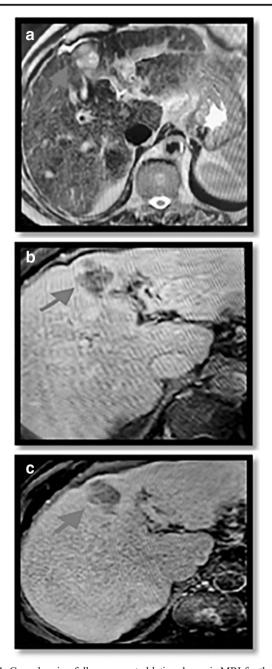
Case showing follow-up post-ablation dynamic MRI for the liver after 3 months, showing left hepatic lobe segment VI-a partially exophytic HCC of about 3 cm (the ablation zone shown by blue arrows showing liquefaction necrosis with small rime of enhancement denoting residual tumoral activity). a Axial T2WI showing high signal with areas of fluid signal representing post-ablation necrosis. b Axial T1WI post contrast image showing minimal rime of residual enhancement denoting tumoral reactivity. c Axial T1WI delayed image showing more evidenced wash out of the enhanced area
